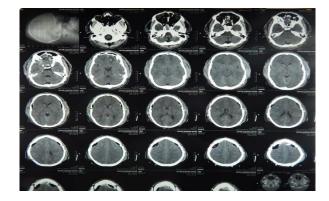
(A): Postoperative CT scan brain of case 3.
